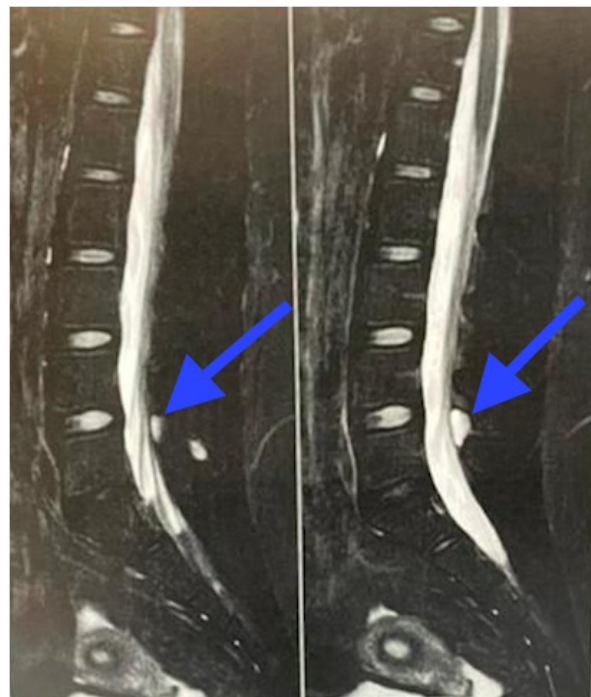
Magnetic resonance imaging (MRI) demonstrating a cerebrospinal fluid fistula, at lumbar level, L4-L5 (blue arrow).
